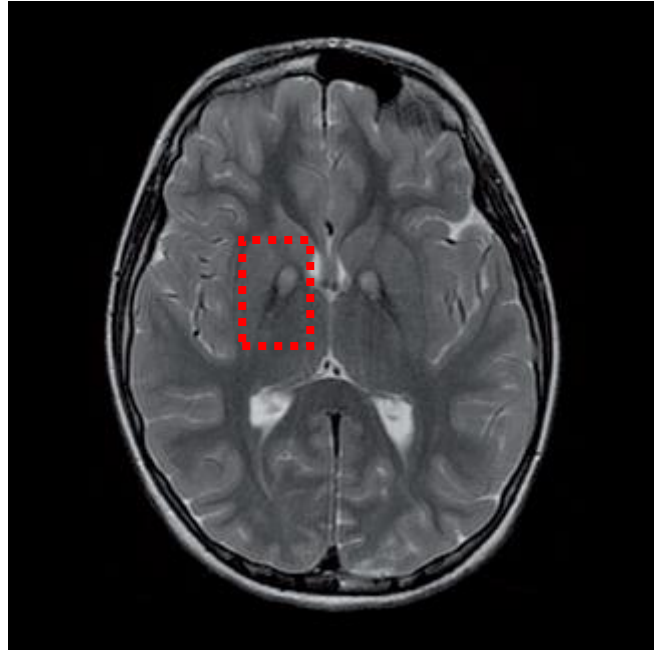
MRI of a PKAN patient. It is shown the classical 'eye of the tiger' sign. Hyperintense (white) signals indicative of tissue rarefaction are seen (centre of red rectangle) surrounded by areas of hypointensity (black areas) attributable to iron accumulation.
